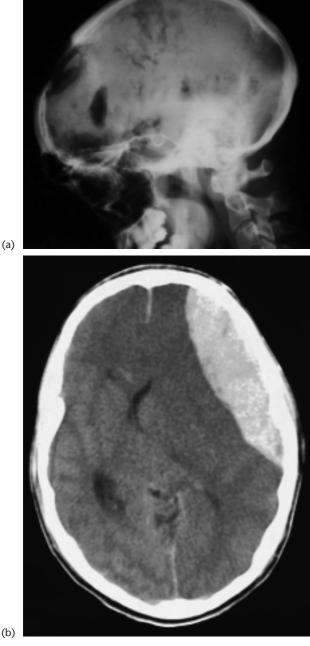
(a) Skull radiograph showing depressed fracture and air within the skull. (b) CT scan showing large extradural haematoma in the right frontal area with compression of the ventricles.
